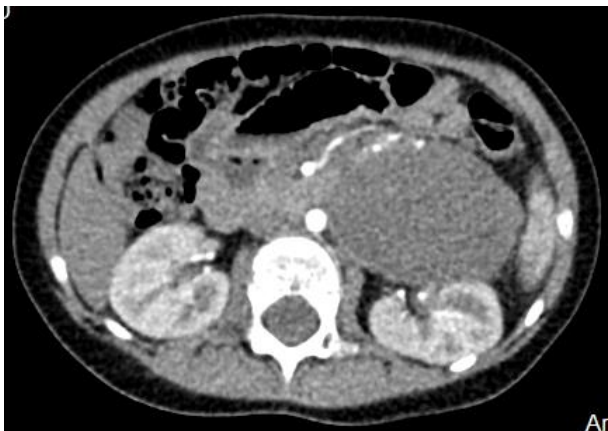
Patient E., 3 years. Contrasted spiral CT of the abdomen (explanations in text)
